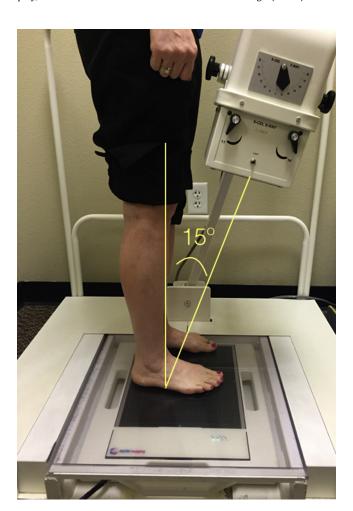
View showing angle of radiograph projection beam.
